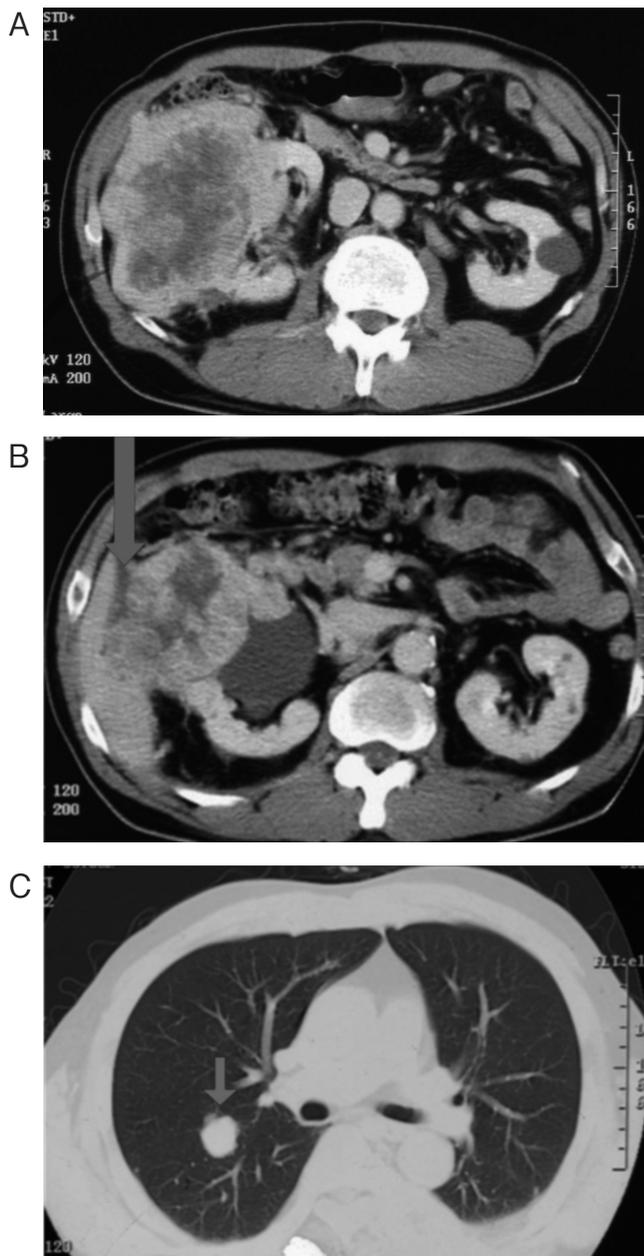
(A, B, C). CT scan at diagnosis. Abdominal CT revealing a 108-mm diameter heterogeneously enhanced mass at the middle pole of the right kidney (A) with direct invasion of the liver (B). Thoracic CT scan showing several nodules with a maximum diameter of 22 mm in the lung (C).
